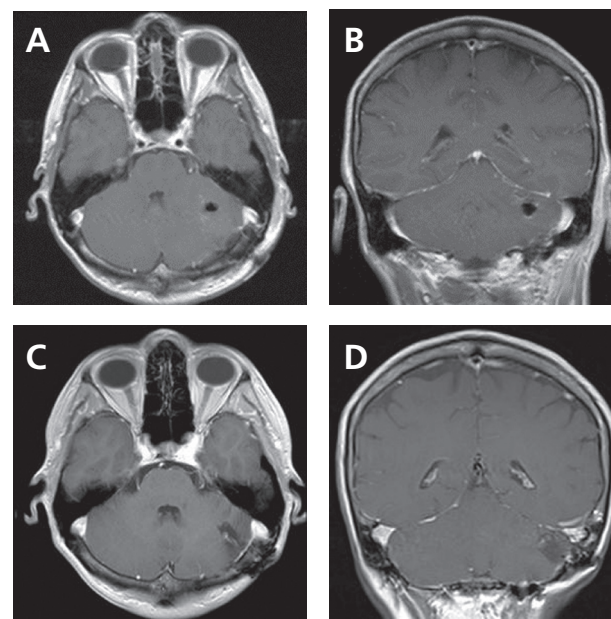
Postoperative MRI at 24 hours after resection. (A) Axial T1-weighted image with gadolinium contrast demonstrates complete tumor resection without residual enhancement in the resection cavity. (B) Coronal T1-weighted image with gadolinium contrast demonstrates cranial-caudal borders of resection cavity without residual enhancement. (C) Axial and (D) coronal T1-weighted images with gadolinium at six-month postoperative follow-up, showing no evidence of recurrent disease.
